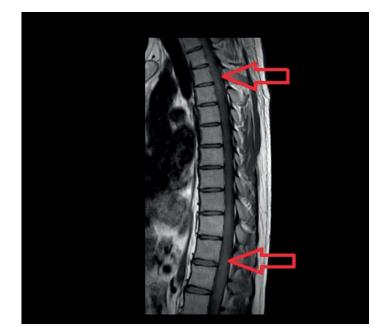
Thoracal spinal MRI.
